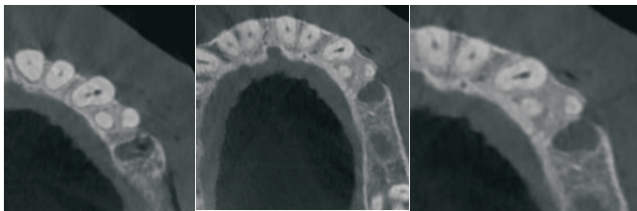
Axial view of CBCT showing 2 canals at the coronal third;merging into 1 at the middle-apical third
